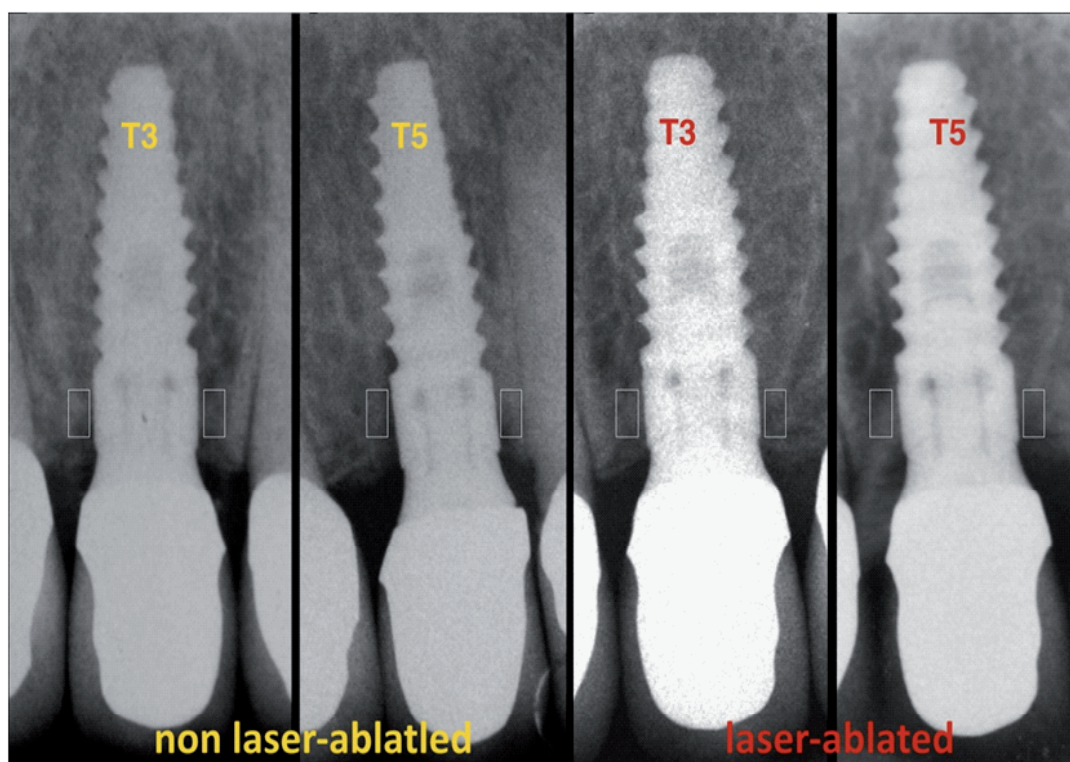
Regions of interest were selected on radiographs taken immediately after prosthesis delivery, after 3 years after loading (T3) and 5 years of loading (T5).
